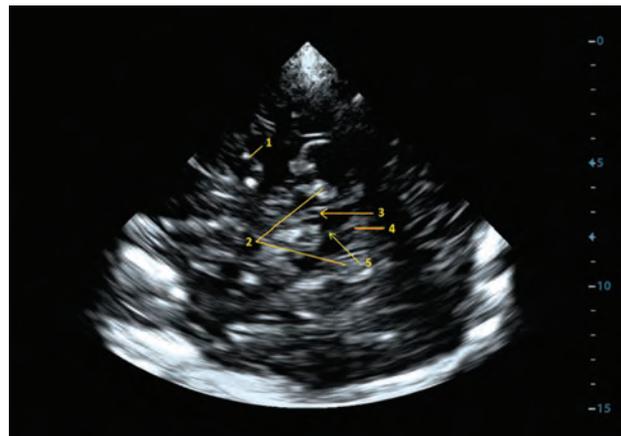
Transcranial sonography: brain stem with the substantia nigra imaged from a transtemporal approach, axial mesencephalic plane. 1) middle cerebral artery, 2) perimesencephalic cisterns, 3) substantia nigra, 4) fourth ventricle, and 5) brain raphe.
